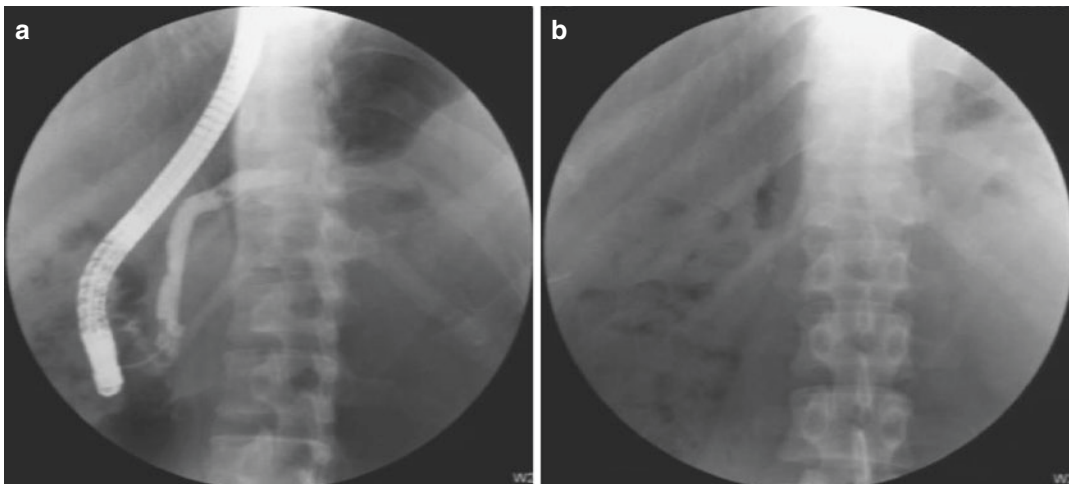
(a) ERCP demonstrated irregular dilation of the entire pancreatic duct and multiple filling defects in the head and body of the pancreatic duct. (b) X-ray demonstrated the disappearance of filling defects after stone extraction
